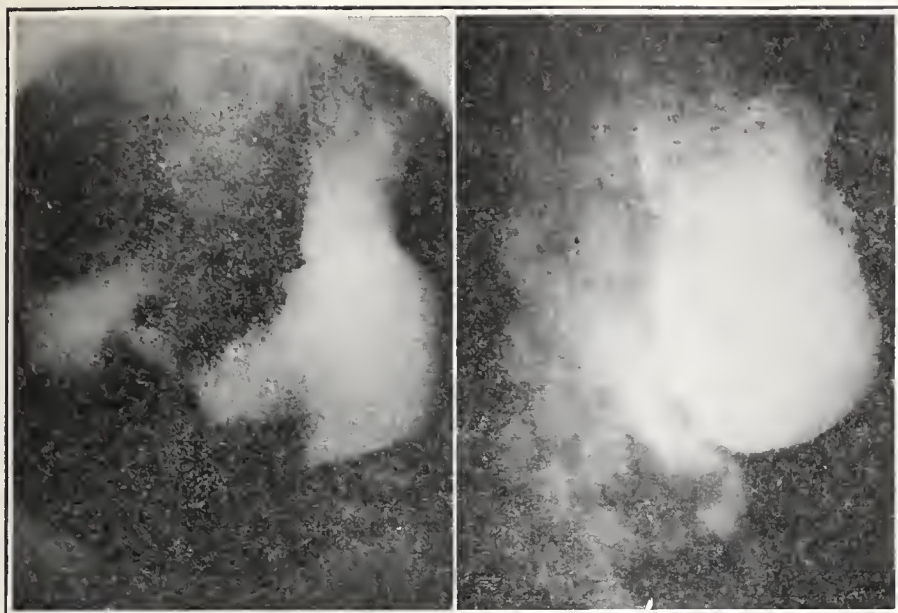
Preoperative x-ray of the stomach.
